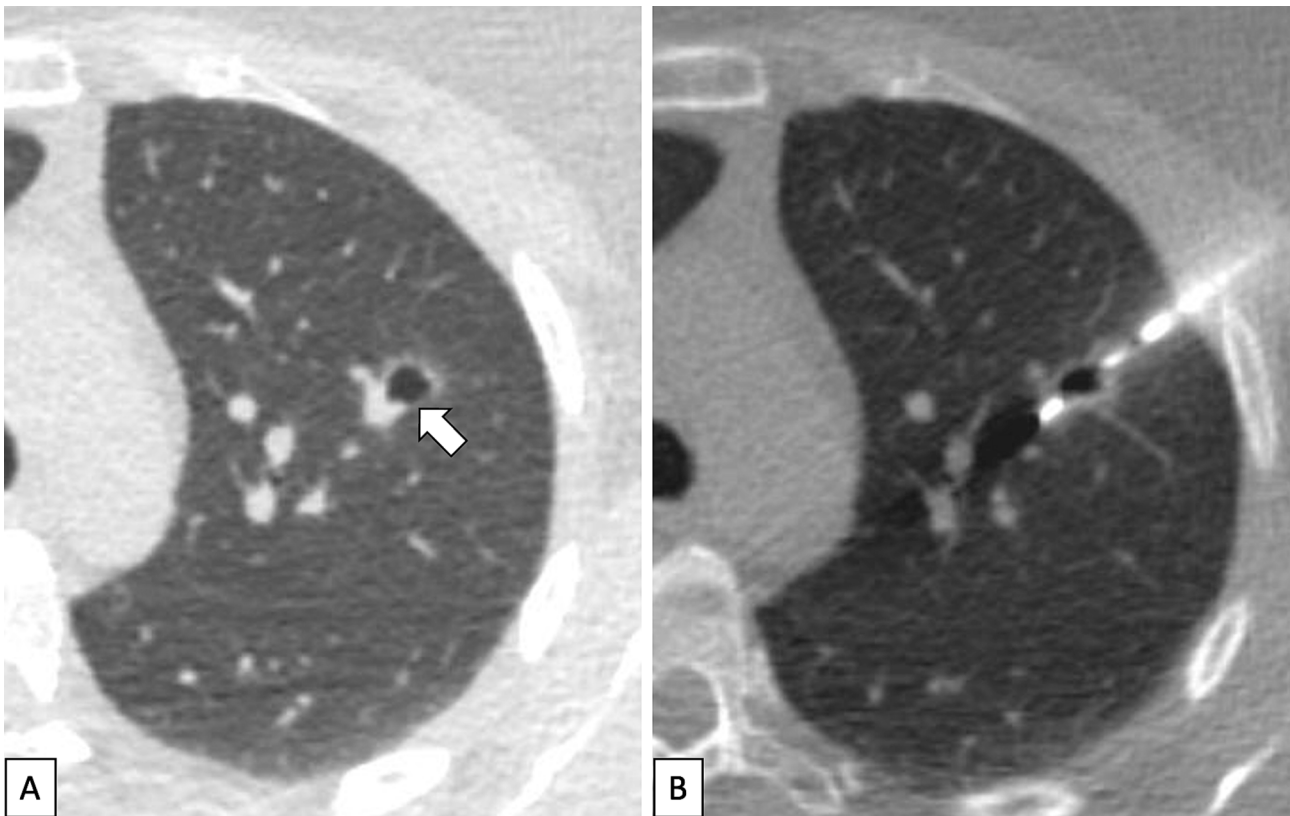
A-B. CT-guided transthoracic core needle biopsy of unilocular cystic airspace lesion located in the left upper lobe (arrow). B. Given the challenges in adopting a tangential approach due to small lesion dimensions, the lesion was transfixing, including both the circumferential thickening and the airspace within the biopsy groove. The final diagnosis was lung adenocarcinoma.
